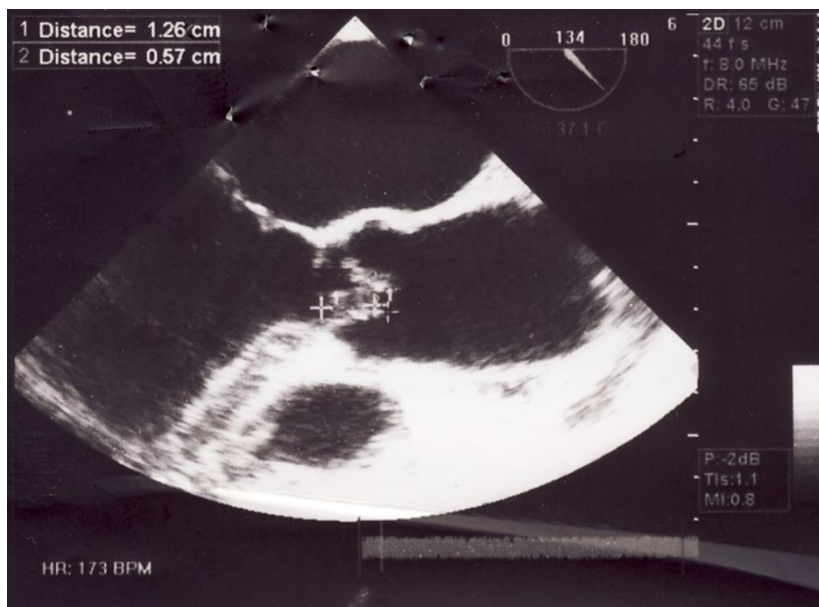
Transthoracic echocardiography (TTE) showed a large mobile vegetation (1.26 × 0.57 cm) on the aortic valve.
